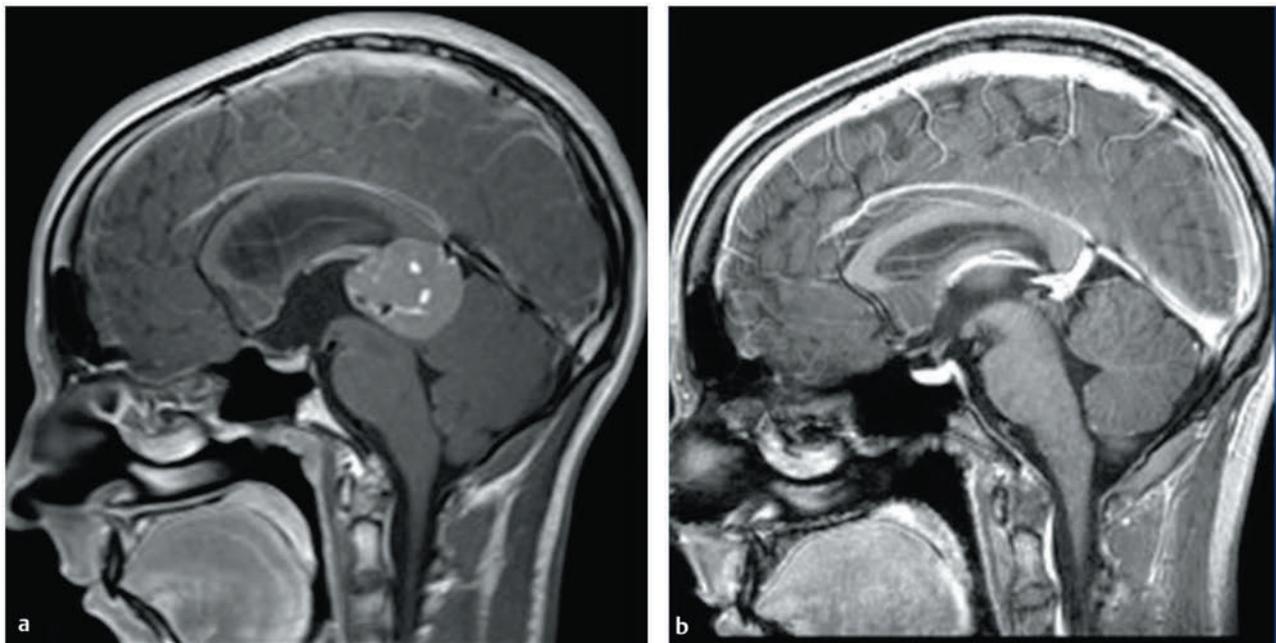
Postcontrast sagittal magnetic resonance image of biopsy-proven germinoma (a) before and (b) 3 months after two cycles of chemotherapy. Note the rapid response of the tumor to the chemotherapy.
